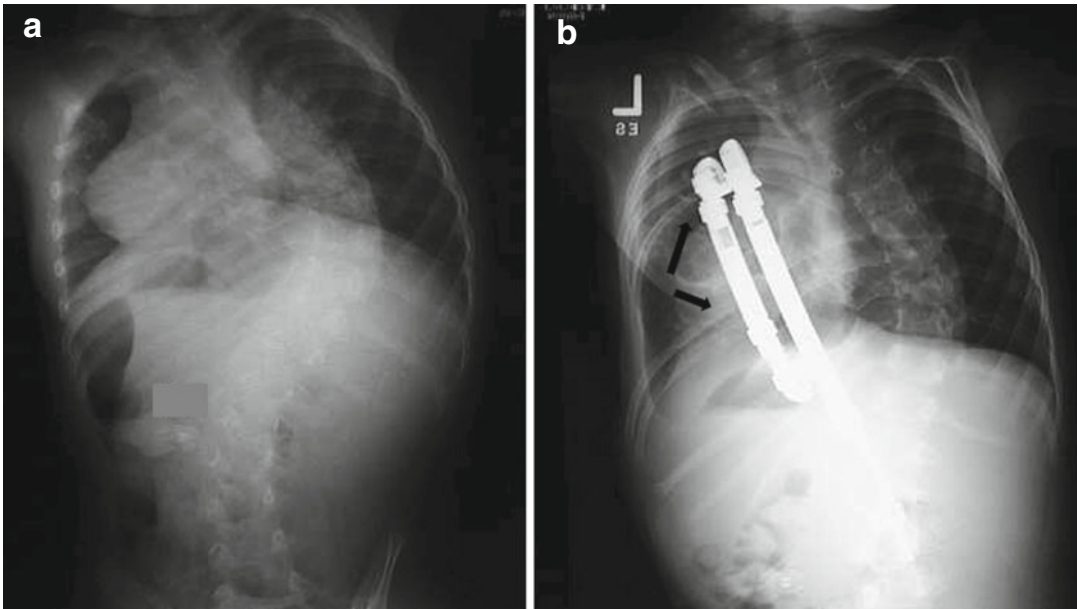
(a, b) Pre- and postoperative radiographs demonstrate large opening of two ribs at a thoracotomy site (between *black arrows*) and compression of rib spaces
